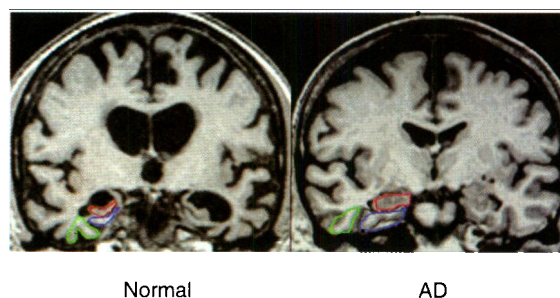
MRI Brain Scans in Early Diagnosis of AD
